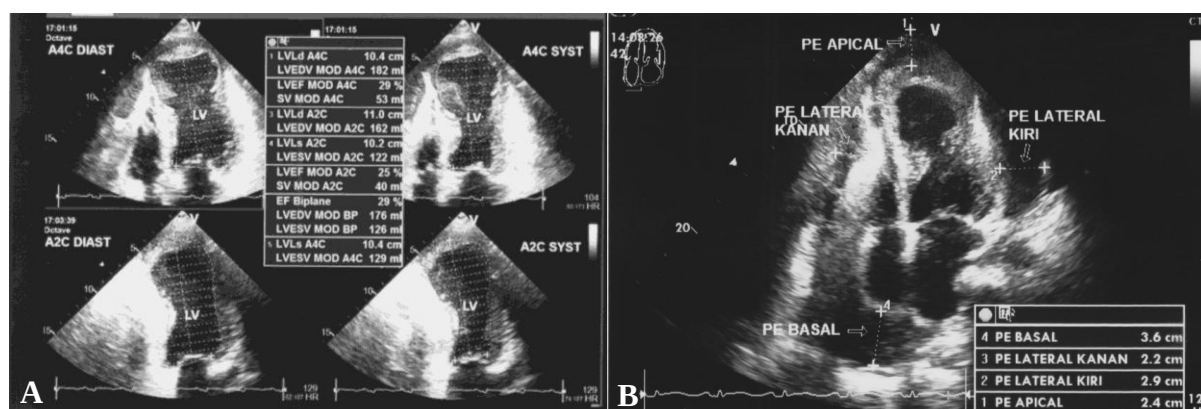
Initial left ventricular echocardiography in the emergency department (A) and echocardiography evaluation revealed massive pericardial effusion (B)
